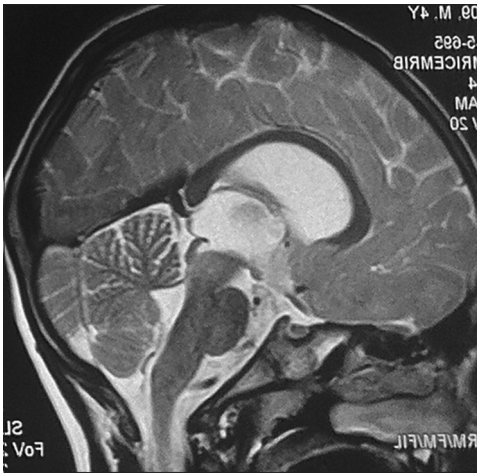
MRI T2 weighted image showing areas of hyper intensity involving brainstem
